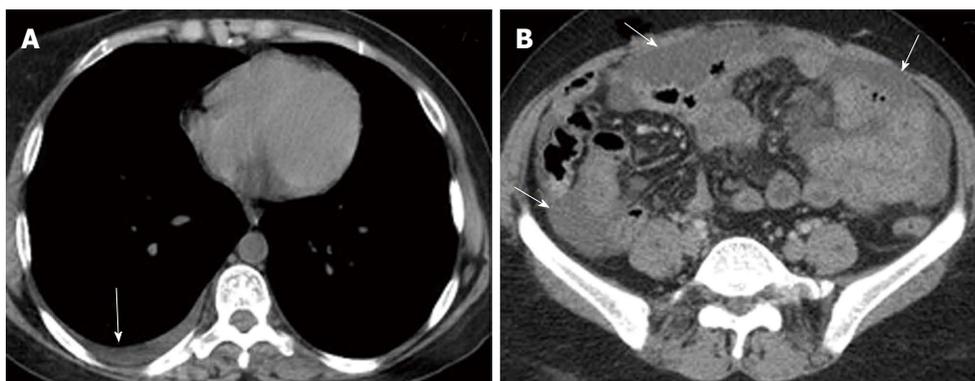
Pre contrast axial computed tomography scan showing (A) mild right-sided pleural effusion and (B) mild ascites.
